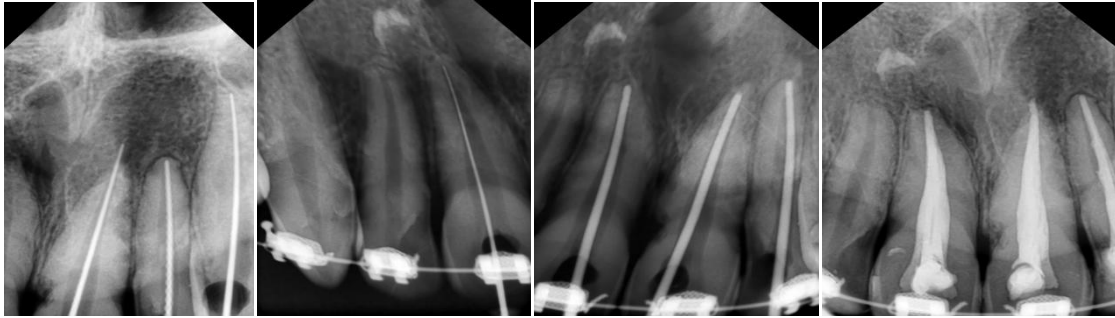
working length radiograph
